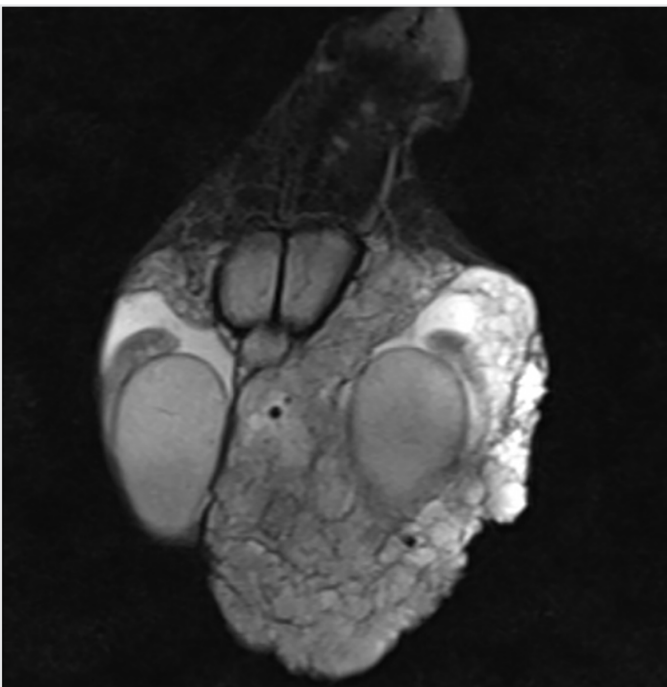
Scrotal MRI image
